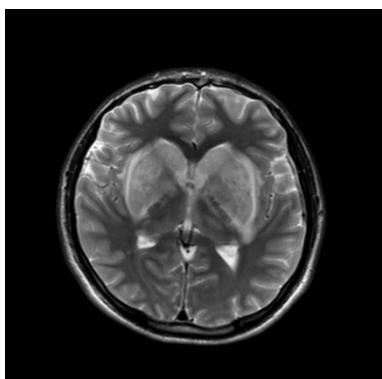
Axial T2 MRI series show hyperintensities in bilateral basal ganglia
